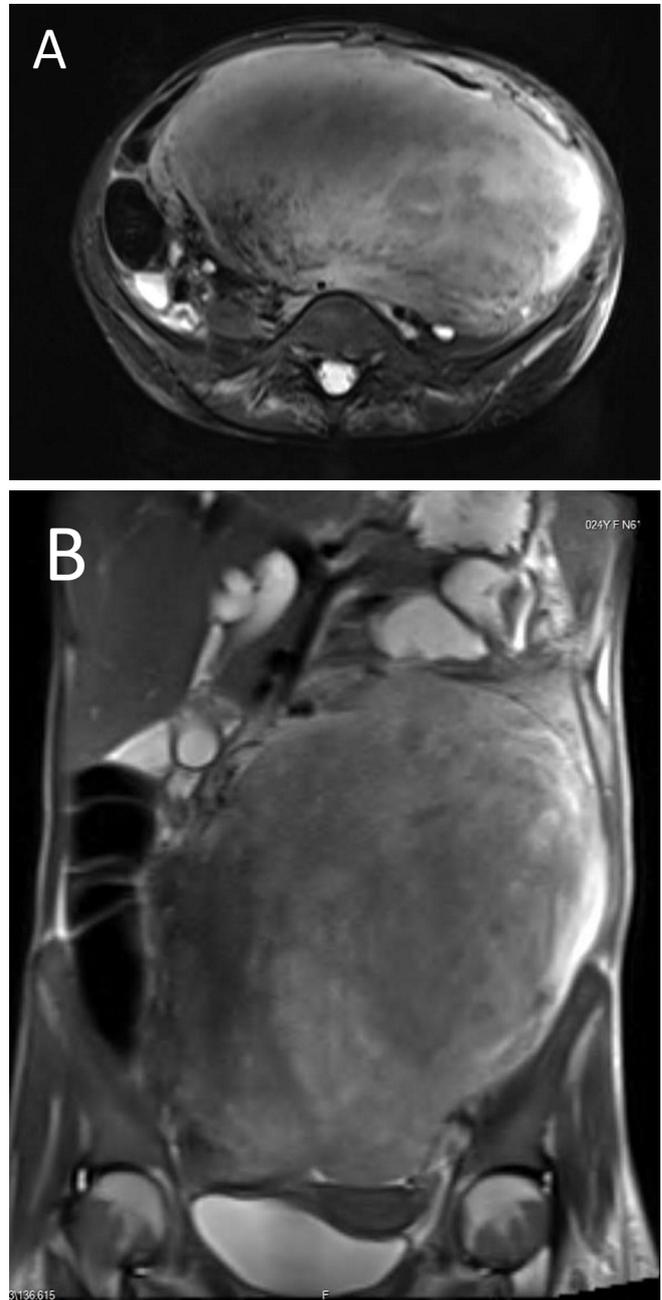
The MRI in axial (A) and coronal (B) view revealed a large abdominal mass pushing the bowel loops to the sides and above, posteriorly compressing the abdominal aorta, the lower part of inferior vena cava, and both ureters causing bilateral hydroureteronephrosis.
